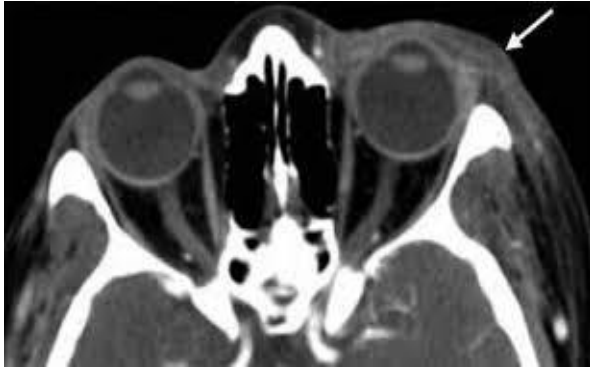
Periorbital. Axial contrast enhanced CT image show's swelling around the left eye.
